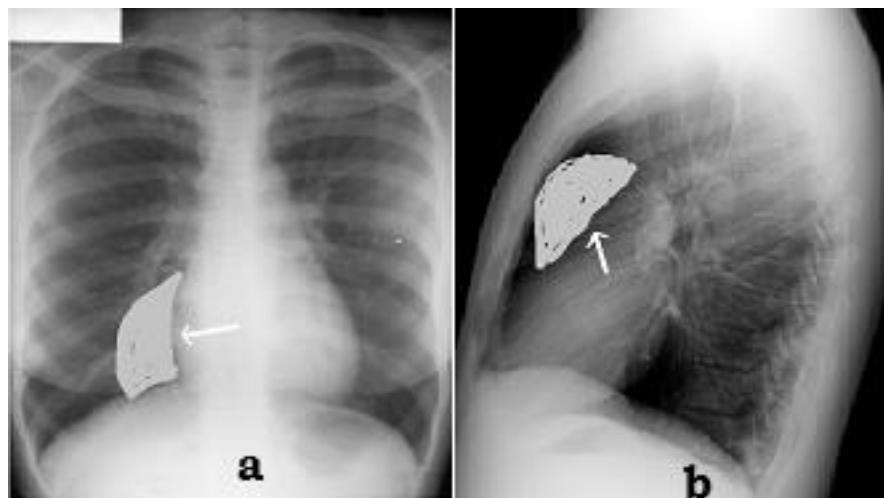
Radiographs showing how the right atrium enlarges. a. Postero-anterior view and b. Lateral view
